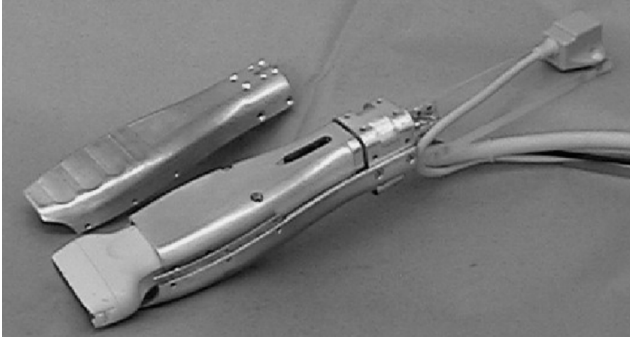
Sensorized ultrasound probe used in the DVT screening system shown, where the outer shell surrounds the ultrasound probe and inner shell. Inner and outer shells are connected at the rear by a force/torque sensor, and a location sensor is mounted on a Plexiglas rod.
